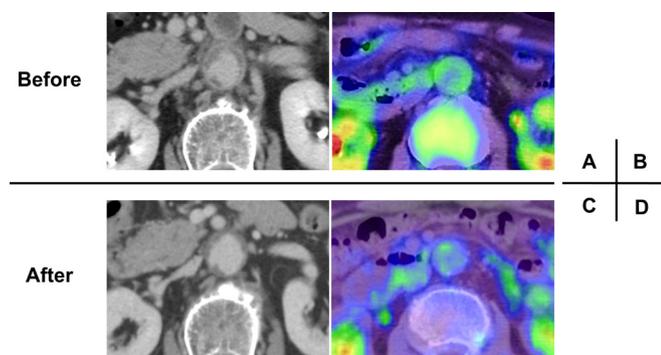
Radiological findings of contrast-enhanced CT and 18F-FDG PET/CT. (A) CT scan with increased contrast enhancement of the aortic wall (day 8). (B) 18F-FDG uptake at the same aortic wall with increased contrast enhancement area (day 16). Mild enlargement of the para-aortic lymph nodes and fat stranding surrounding the aorta are noted, indicating inflammation of the para-aortic region. (C) CT scan with decrease in contrast enhancement of the aortic wall (46 days after admission). (D) Lower 18F-FDG uptake at the same place as that in (B) (46 days after admission). FDG, fluorodeoxyglucose; PET, positron emission tomography.
